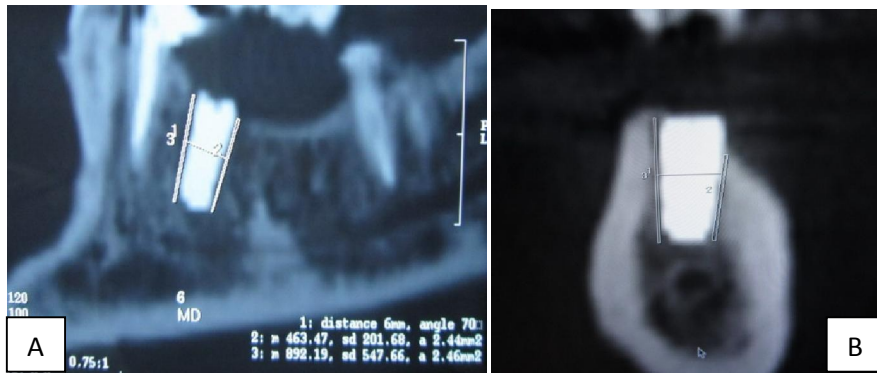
Panoramic reformatted CT scan showing bone mineral density assessment along the mesial and distal surfaces of the implant. Fig.1b: Coronal CT scan showing bone mineral density assessment along the buccal and lingual surfaces of the implant
